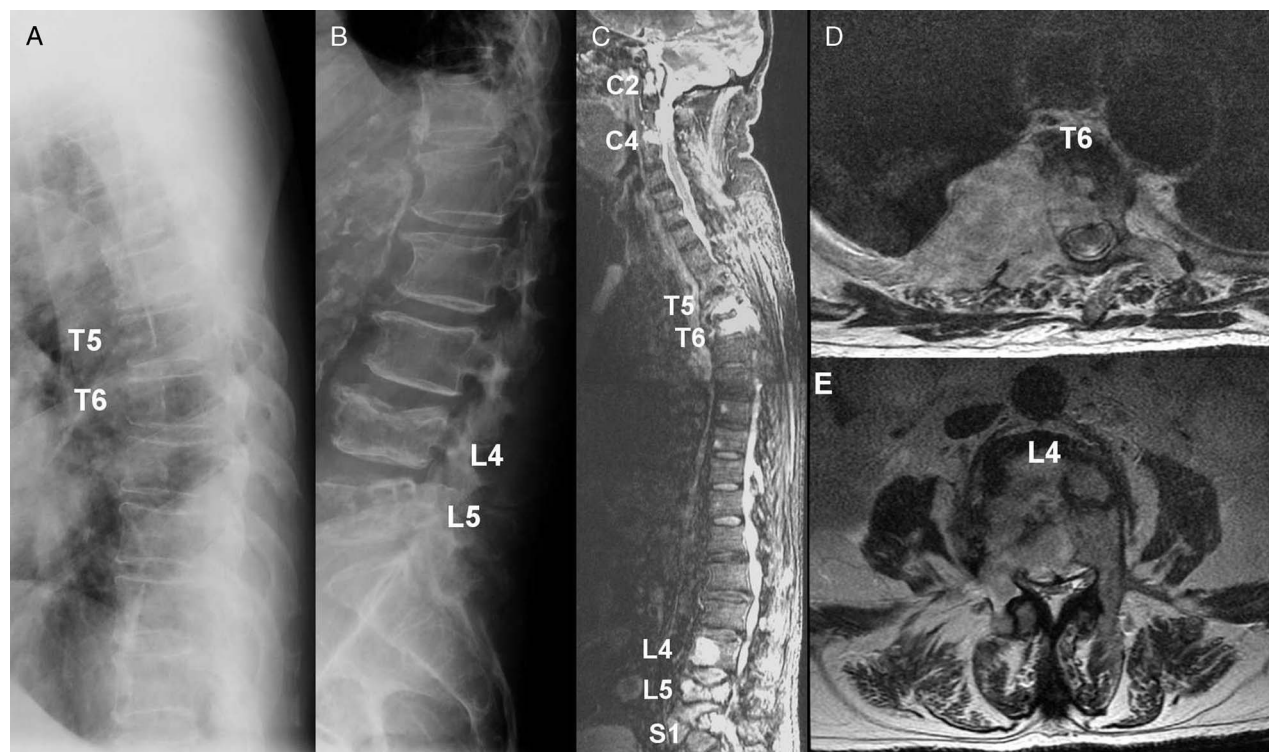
This 77-year-old man with diagnosis of MM presented with multiple expansive lesions in the right ribs. Dorsal (A) and lumbar (B) spine radiographies did not describe bone lesions on initial review. In retrospect, T5 and T6 may be more lucent than the adjacent vertebra. L4 and L5 compressions were initially interpreted as likely osteoporotic compression fractures. Whole column MR showed multiple bone lesions in cervical, thoracic, and lumbar levels (C). Thoracic axial STIR images (D) showed T6 tumor with posterior element invasion and impending cord compression. Lumbar axial STIR images (E) showed a prevertebral soft tissue mass and compression of the vertebral canal and nerve roots.
